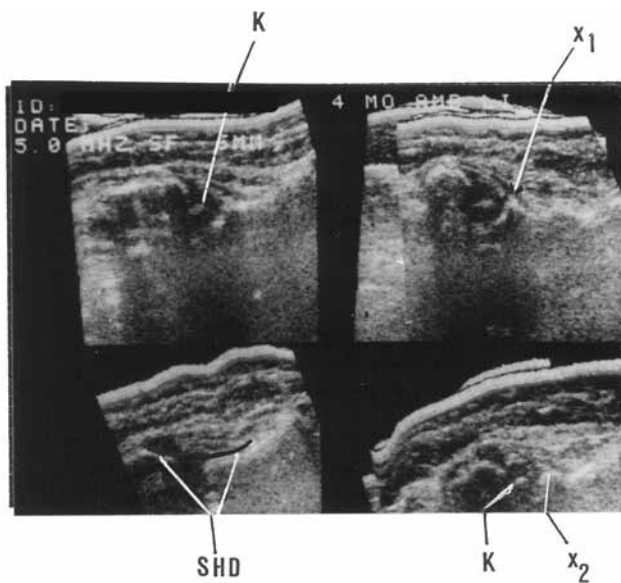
One of the very first hip sonograms (1979) made with a compound transducer, the nucleus is marked with "K".
